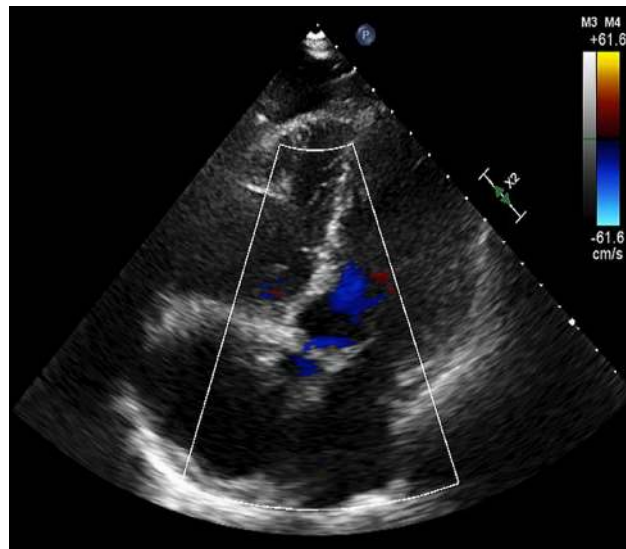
Apical four-chamber view of heart on transthoracic echocardiography showing global hypokinesis of right and left ventricles.
